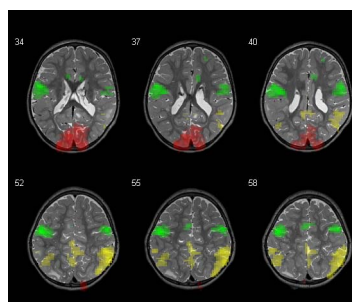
ICA derived networks for subject 2: motor (green), visual (red) and REST (yellow) networks, overlaid on T2-axial MRI
